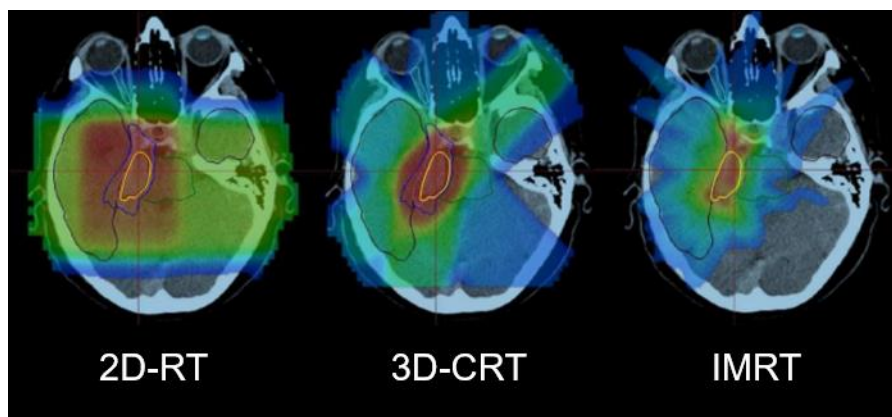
Dose distributions in an axial CT slice of the same patient using 2D-RT, 3D-CRT and IMRT. The red areas represent higher doses and the blue areas lower doses. It can be seen the progressively larger high-dose conformation to the target volume (yellow contour), as well as normal tissue sparing [19].
